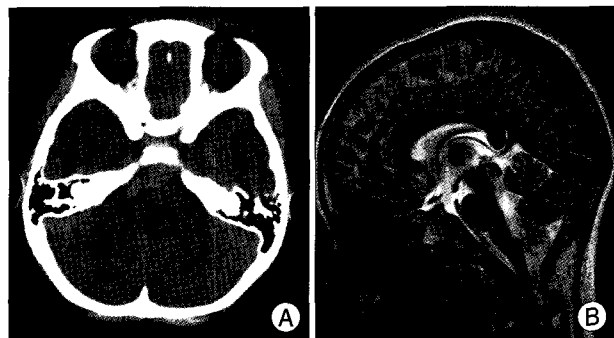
Brain computed tomography scan (A) showing high density on retroclival area and brain T2-weighted magnetic resonance sagittal image (B) of 2 months after trauma showing nearly total resolving of previous hematoma.
